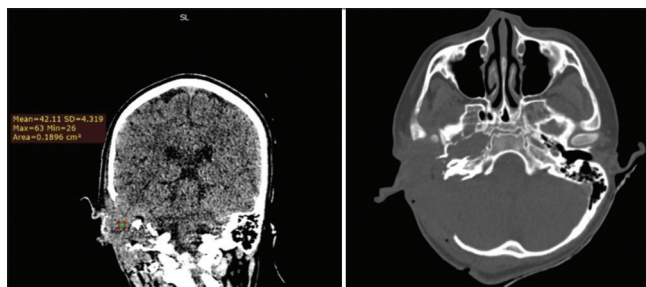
Head computed tomography with contrast in coronal view, soft-tissue solid mass enhancement, irregular border, like in the right jugular fossa that exophytic to the middle ear, meso, and hypotympanum until right external meatus, with destruction in the right mastoid and right temporal.
